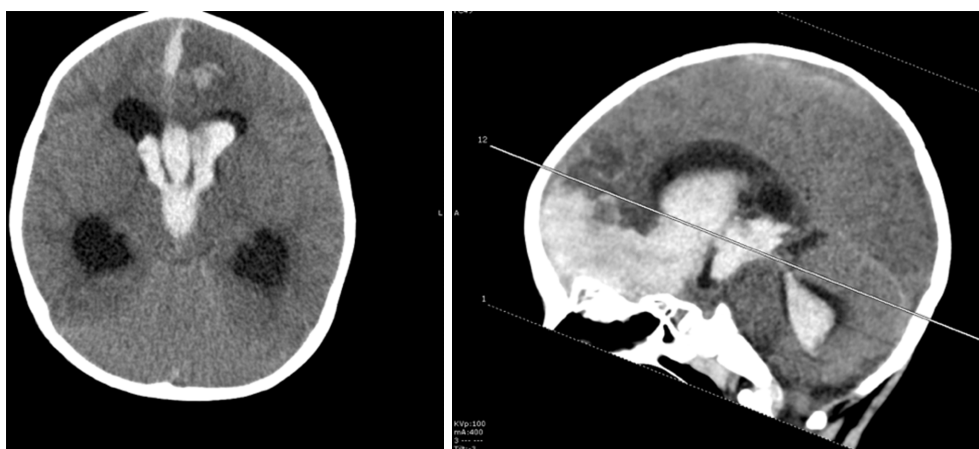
Computed tomography head non-contrasted axial (left) and sagittal (right) imaging demonstrates the large left frontal hematoma with diffused intraventricular hemorrhage and ventriculomegaly.
